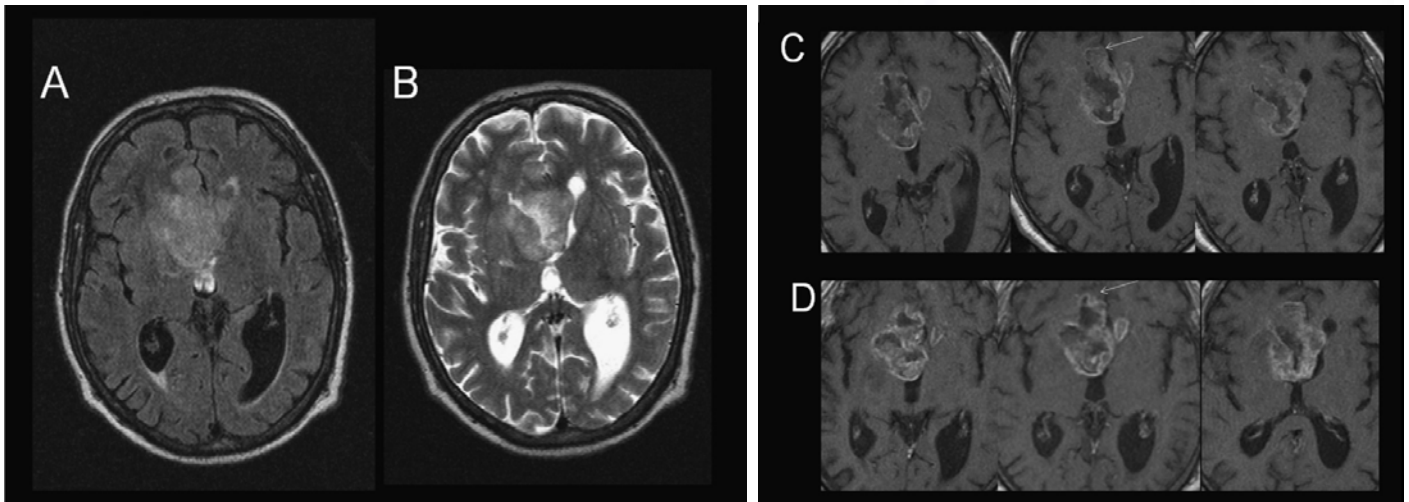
69-year-old male with butterfly glioma. (A, B) FLAIR and T2W images using Gadavist shows the typical butterfly appearance and infiltration of the partially necrotic tumor into both frontal lobes. Three consecutive T1W images were acquired after a single dose of Dotarem (C) and Gadavist (D). Because of the higher concentration formulation of Gadavist, the enhancement margins are better defined and the internal structures of the tumor are better differentiated.
